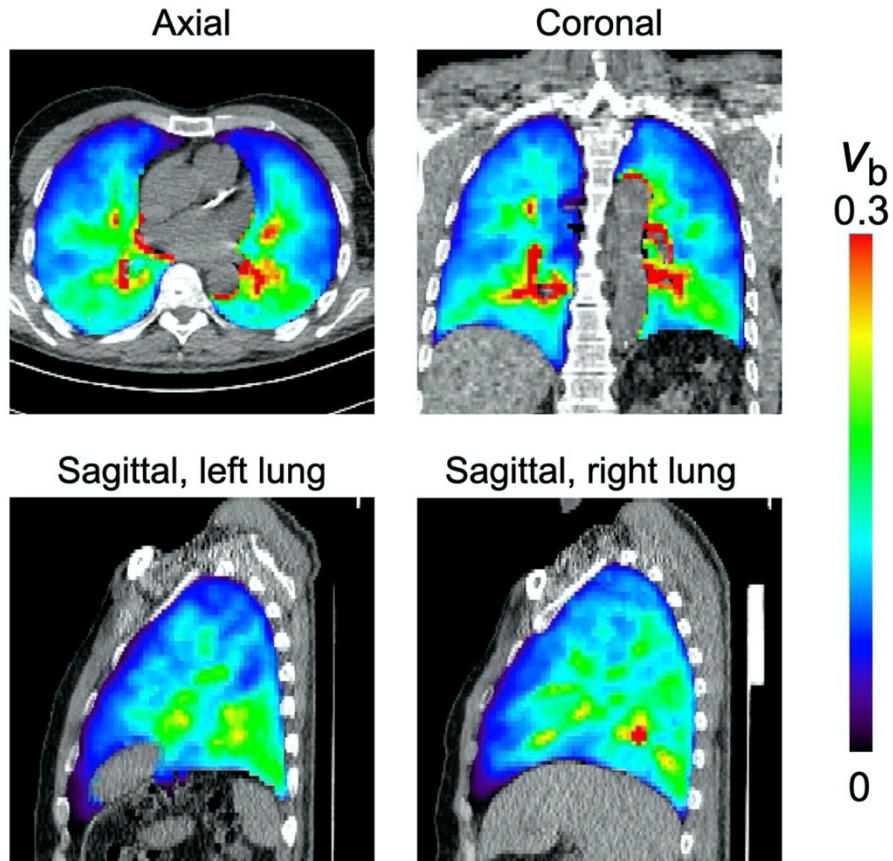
Parametric images of the fractional blood volume v_b generated with the proposed IDIF-T-D model for the lungs of one example subject. The images are overlaid on corresponding CT images.
